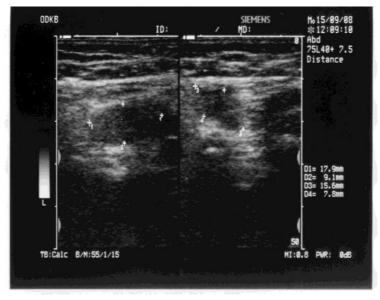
Patient D., 4 years, case history № 3978. Ultrasound picture of a left-sided abdominal cryptorchidism before surgery.
